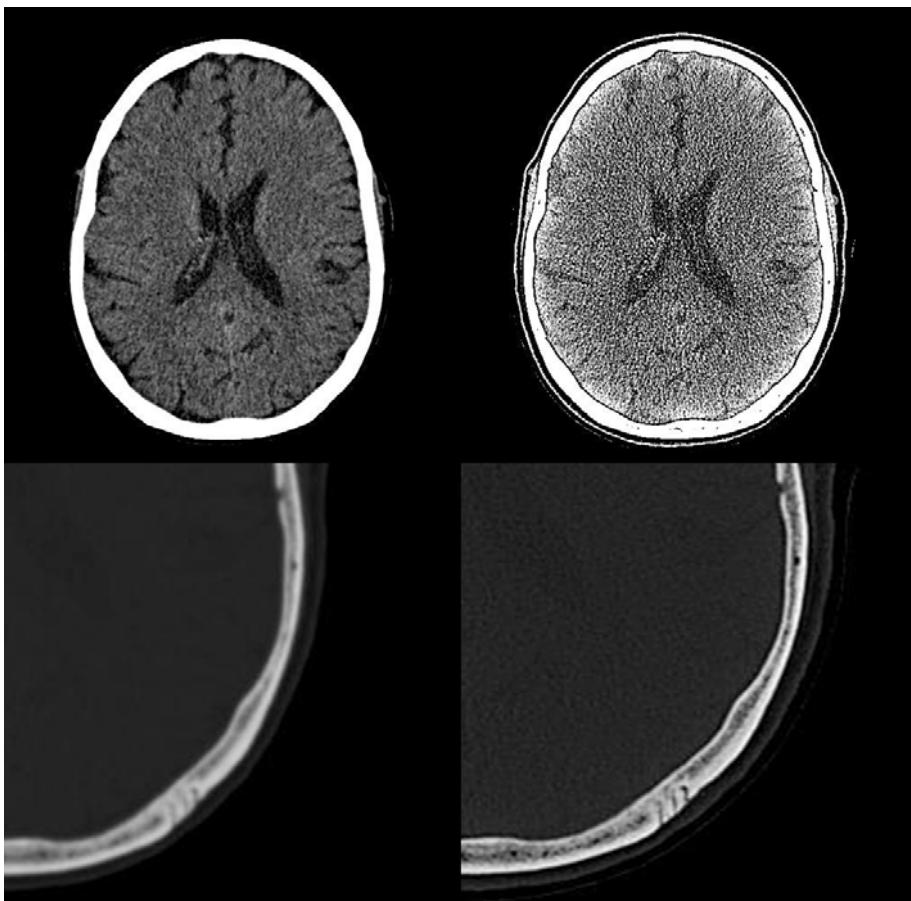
Four CT head images. Images on the left are reconstructed with a soft tissue reconstruction filter; images on the right are reconstructed with a bone reconstruction filter.
